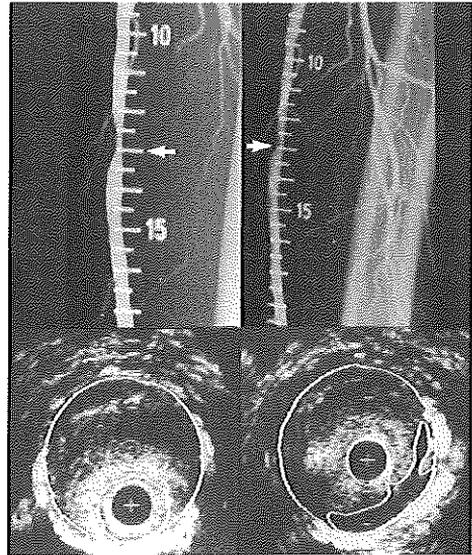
Corresponding intravascular ultrasound cross-sections and angiograms obtained from a patient before and after balloon angioplasty (PTA) (Group II: angiographic diameter stenosis <50%). Before PTA the smallest free lumen area is seen at level 13 cm. The lesion involved was eccentric and soft in nature. After PTA the lesion became dissected from the arterial wall (dissection = 150°). The free lumen area (FLA; inner contour) and media-bounded area (MBA; outer contour) display the quantitative results. The FLA increased from 3.8 mm² to 4.6 mm²; the MBA increased from 20.3 mm² to 21.0 mm²; the plaque area decreased from 16.5 to 16.4 mm²; and the free lumen diameter increased from 2.2 mm to 2.4 mm. As restenosis developed within 1 month, the patient was referred for repeat balloon angioplasty: + = catheter; calibration = 1 mm.
